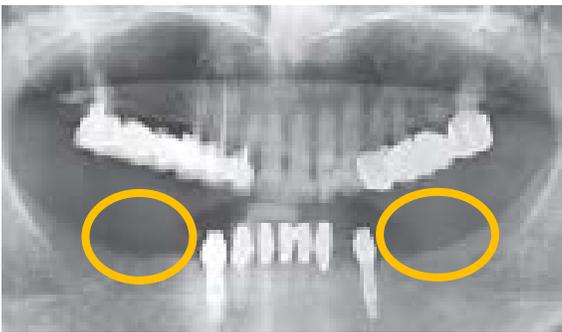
Pre-operative radiograph prior to ridge augmentation.
